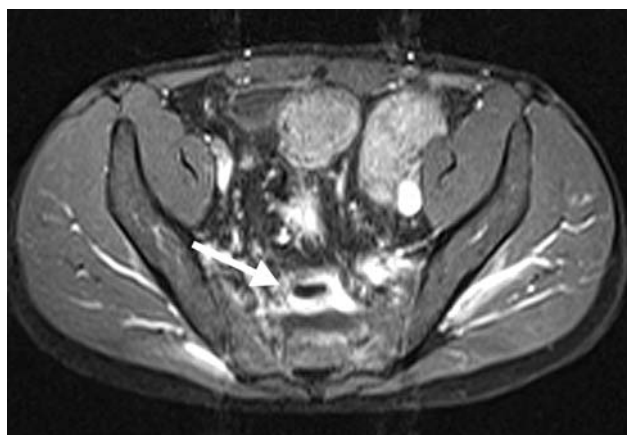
Post-contrast axial fat-saturated T1-weighted MR image shows a rim enhancement of an abscess (*arrow*) in the presacral region.
